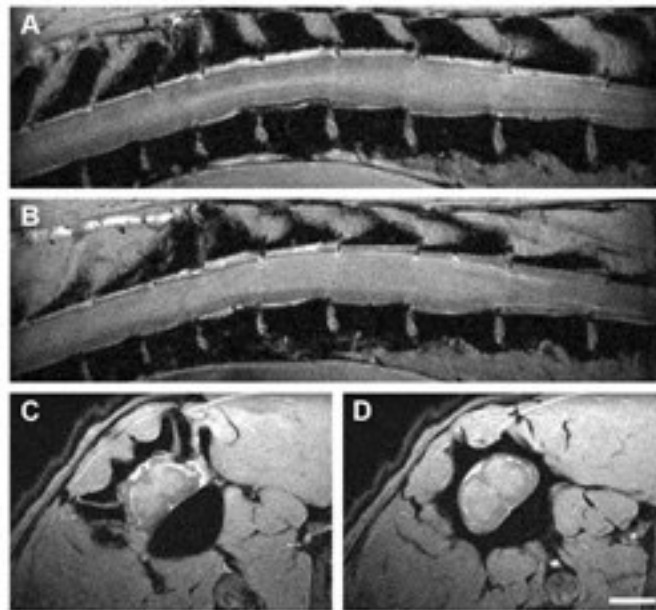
In vivo MRI of intact spinal cord at 17.6 T. A,B show sagittal scans through the thoracic spinal cord. Acquisition parameters: slice thickness 239 μm , FOV 40 x 30 mm, in plane resolution 156 x 117 μm , TR approx. 200 ms (depending on heart rate), TE 4.4 ms. C,D display axial scans through the thoracic spinal cord. Acquisition parameters: slice thickness 500 μm , FOV 17.7 x 35.5 mm, in plane resolution 69x69 μm , TR and TE as above. Scale bar 2 mm (A) A more lateral sagittal scan depicts primarily white matter (lower signal) with some longitudinally oriented more hyperintense structure, reflecting the gray matter of the lateral ventral horn. Cerebrospinal fluid appears hyperintense, vertebral bodies are hypointense. (B) Most of the spinal cord parenchyma displayed here represents gray matter (hyperintense) surrounded by white matter tracts (hypointense) in a paramedian sagittal scan through the spinal cord. (C) An axial scan through the thoracic spinal cord allows the clear distinction between the typical butterfly appearance of the spinal cord gray matter and the surrounding hypointense white matter. Also of note, spinal roots can be clearly identified at this level. (D) A subsequent scan more caudally shows the spinal cord in cross-section away from the spinal root entry zone.
